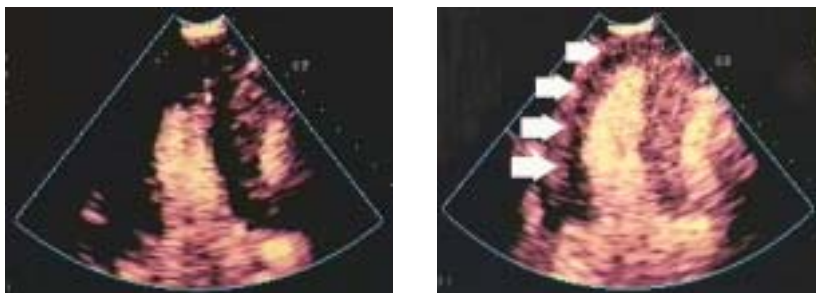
Examples of normal myocardial contrast enhancement and contrast defect detected by real time myocardial contrast echocardiography using low mechanical index. (A) A normal subject ; The first endsystolic frame after microbubble destruction with high mechanical index ultrasound. LV wall is visualized as black due to absence of signals from the microbubbles(left). Note even enhancement of LV wall with the replenished microbubbles at the 10th endsystolic frame(right). (B) A patient with the left anterior descending artery and the left circumflex artery stenoses ; The first endsystolic frame after the microbubble destruction(left). Non-enhancement at the apex and the lateral wall of the LV(arrows) is prominent at the 10th endsystolic frame due to the perfusion abnormality(right).
